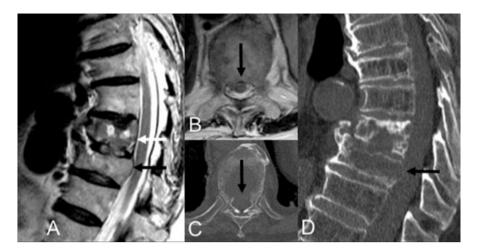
Assessment of the posterior vertebral body cortex. T2-weighted MRI (a) shows altered signal in the T9 (*white arrow*) and T10 (*black arrow*) vertebral bodies from tumor replacement. Axial T2 MRI (b) demonstrates mild epidural extension, but the posterior vertebral body wall integrity is difficult to assess (*arrow*). Axial CT (c) and sagittal CT (d) better show the loss of integrity of part of the vertebral body cortex, which should be taken into account when considering vertebral augmentation
